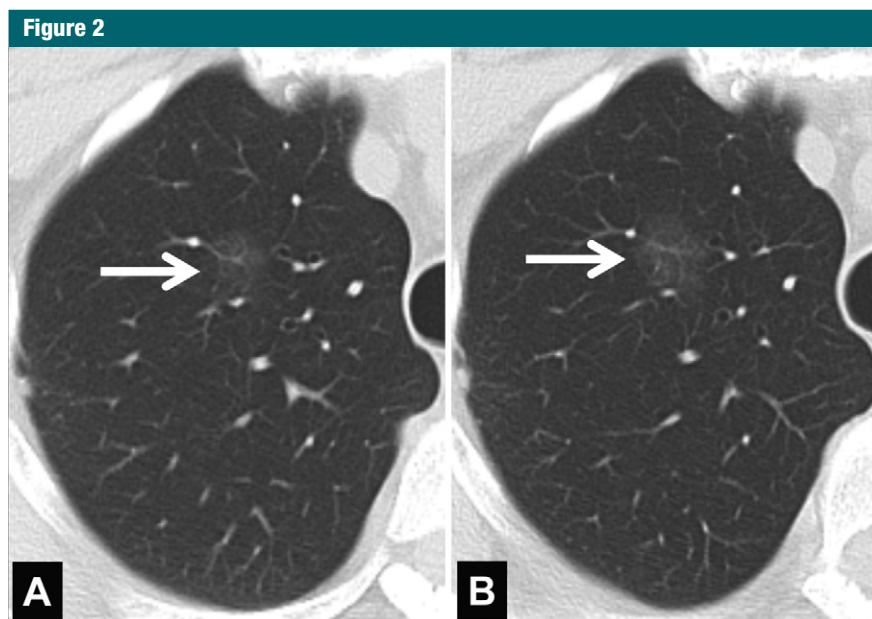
Value of contiguous 1-mm-thick CT scans for establishing subtle interval growth. *A*, Magnified section through right upper lobe shows a subtle pure GGN (arrow). *B*, Follow-up scan obtained 20 months later allows comparison at precisely the same anatomic level, which is easily confirmed by comparison of adjacent vessels. In this case, a subtle increase in lesion size (arrow) is definitively established. Follow-up resection documented stage IA lepidic invasive adenocarcinoma.
